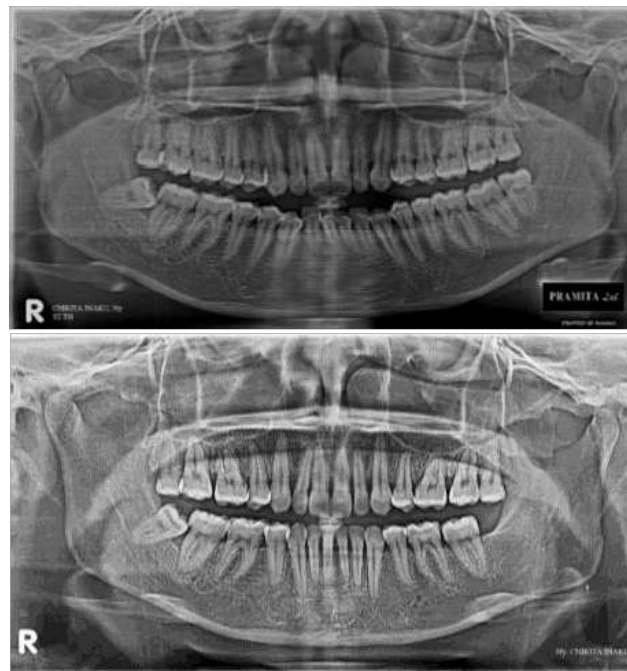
Panoramic radiograph (A) before and (B) after treatment (Source: Personal Documentation)
